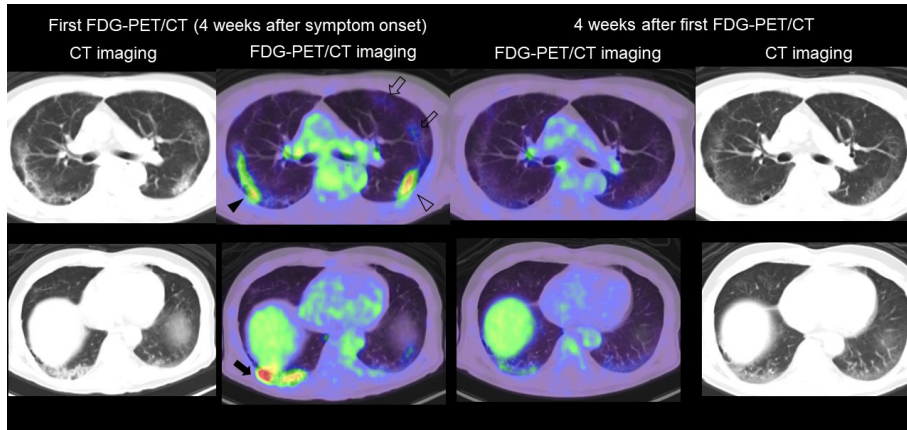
FDG-PET/CT imaging of lung lesion in COVID-19. Left side: CT and fused FDG-PET/CT image of the chest in the first examination (4 weeks after symptom onset). Right side: CT and fused FDG-PET/CT image of the chest (4 weeks after the first FDG-PET/CT examination). Intense FDG uptake was seen in liner opacity (black arrowhead), reticular opacity with consolidation (black arrow), and grand glass opacity with consolidation (open arrowhead) in the lung. Moderate FDG uptake was confirmed in grand glass opacity (open arrows) at the left upper lobe. All the FDG uptake in the first examination was significantly decreased in the second PET/CT scan.
